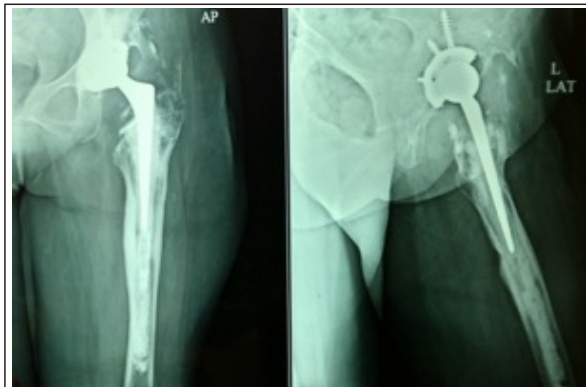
a-Pre-op X-ray of Infected Hip
